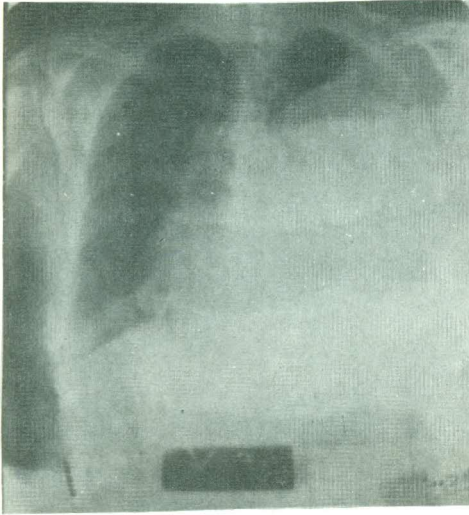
Localized mesothelioma. Initial x-ray showing Lt. near total opacity with contra-lateral mediastinal shift.
